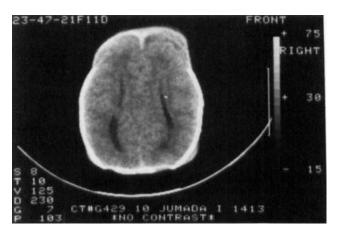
Case 1. CT scan showing parallel lateral ventricles with mild dilatation of occipital horns consistent with callosal agenesis.
